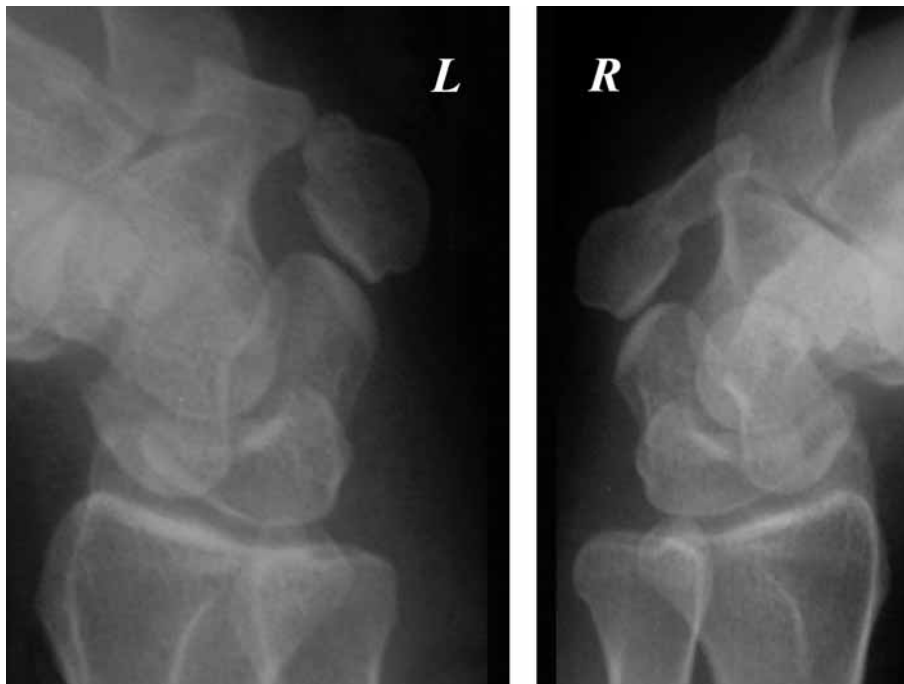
Oblique radiographs of both wrists showing the morphology of the pisohamate coalition on both sides (R : right wrist, L : left wrist).
